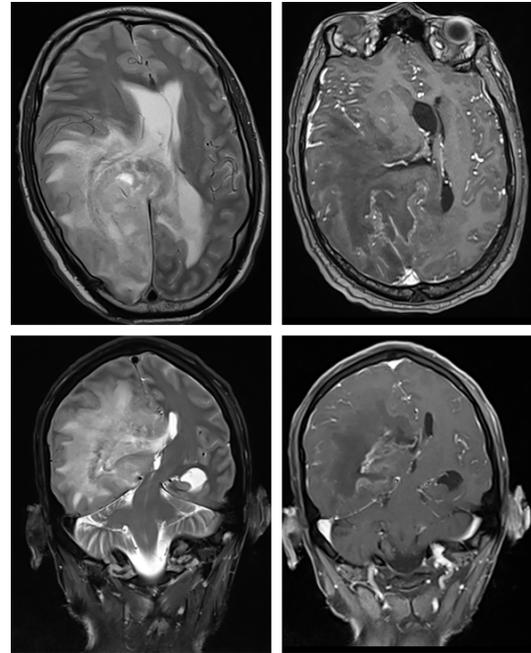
Brain MRI showing a high-density aggressive mass centered on the corpus callosum more to the right side, involving right frontal, parietal and temporal deep white matter crossing the midline at the level of the splenium. Associated with restricted diffusion, micro-hemorrhages and significant mass effect with a leftward midline shift suggestive of glioma.
